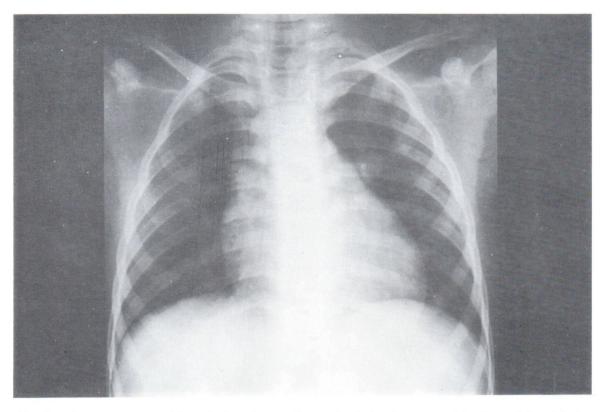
Post treatment with oral phosphate radiograph of the chest, reveal healing of the rickets.
